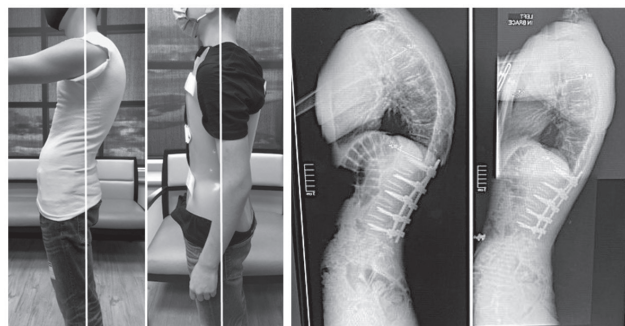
Photographic (Panel A) and radiographic (Panel B) representation of patient pre- and post-orthotic treatment.
